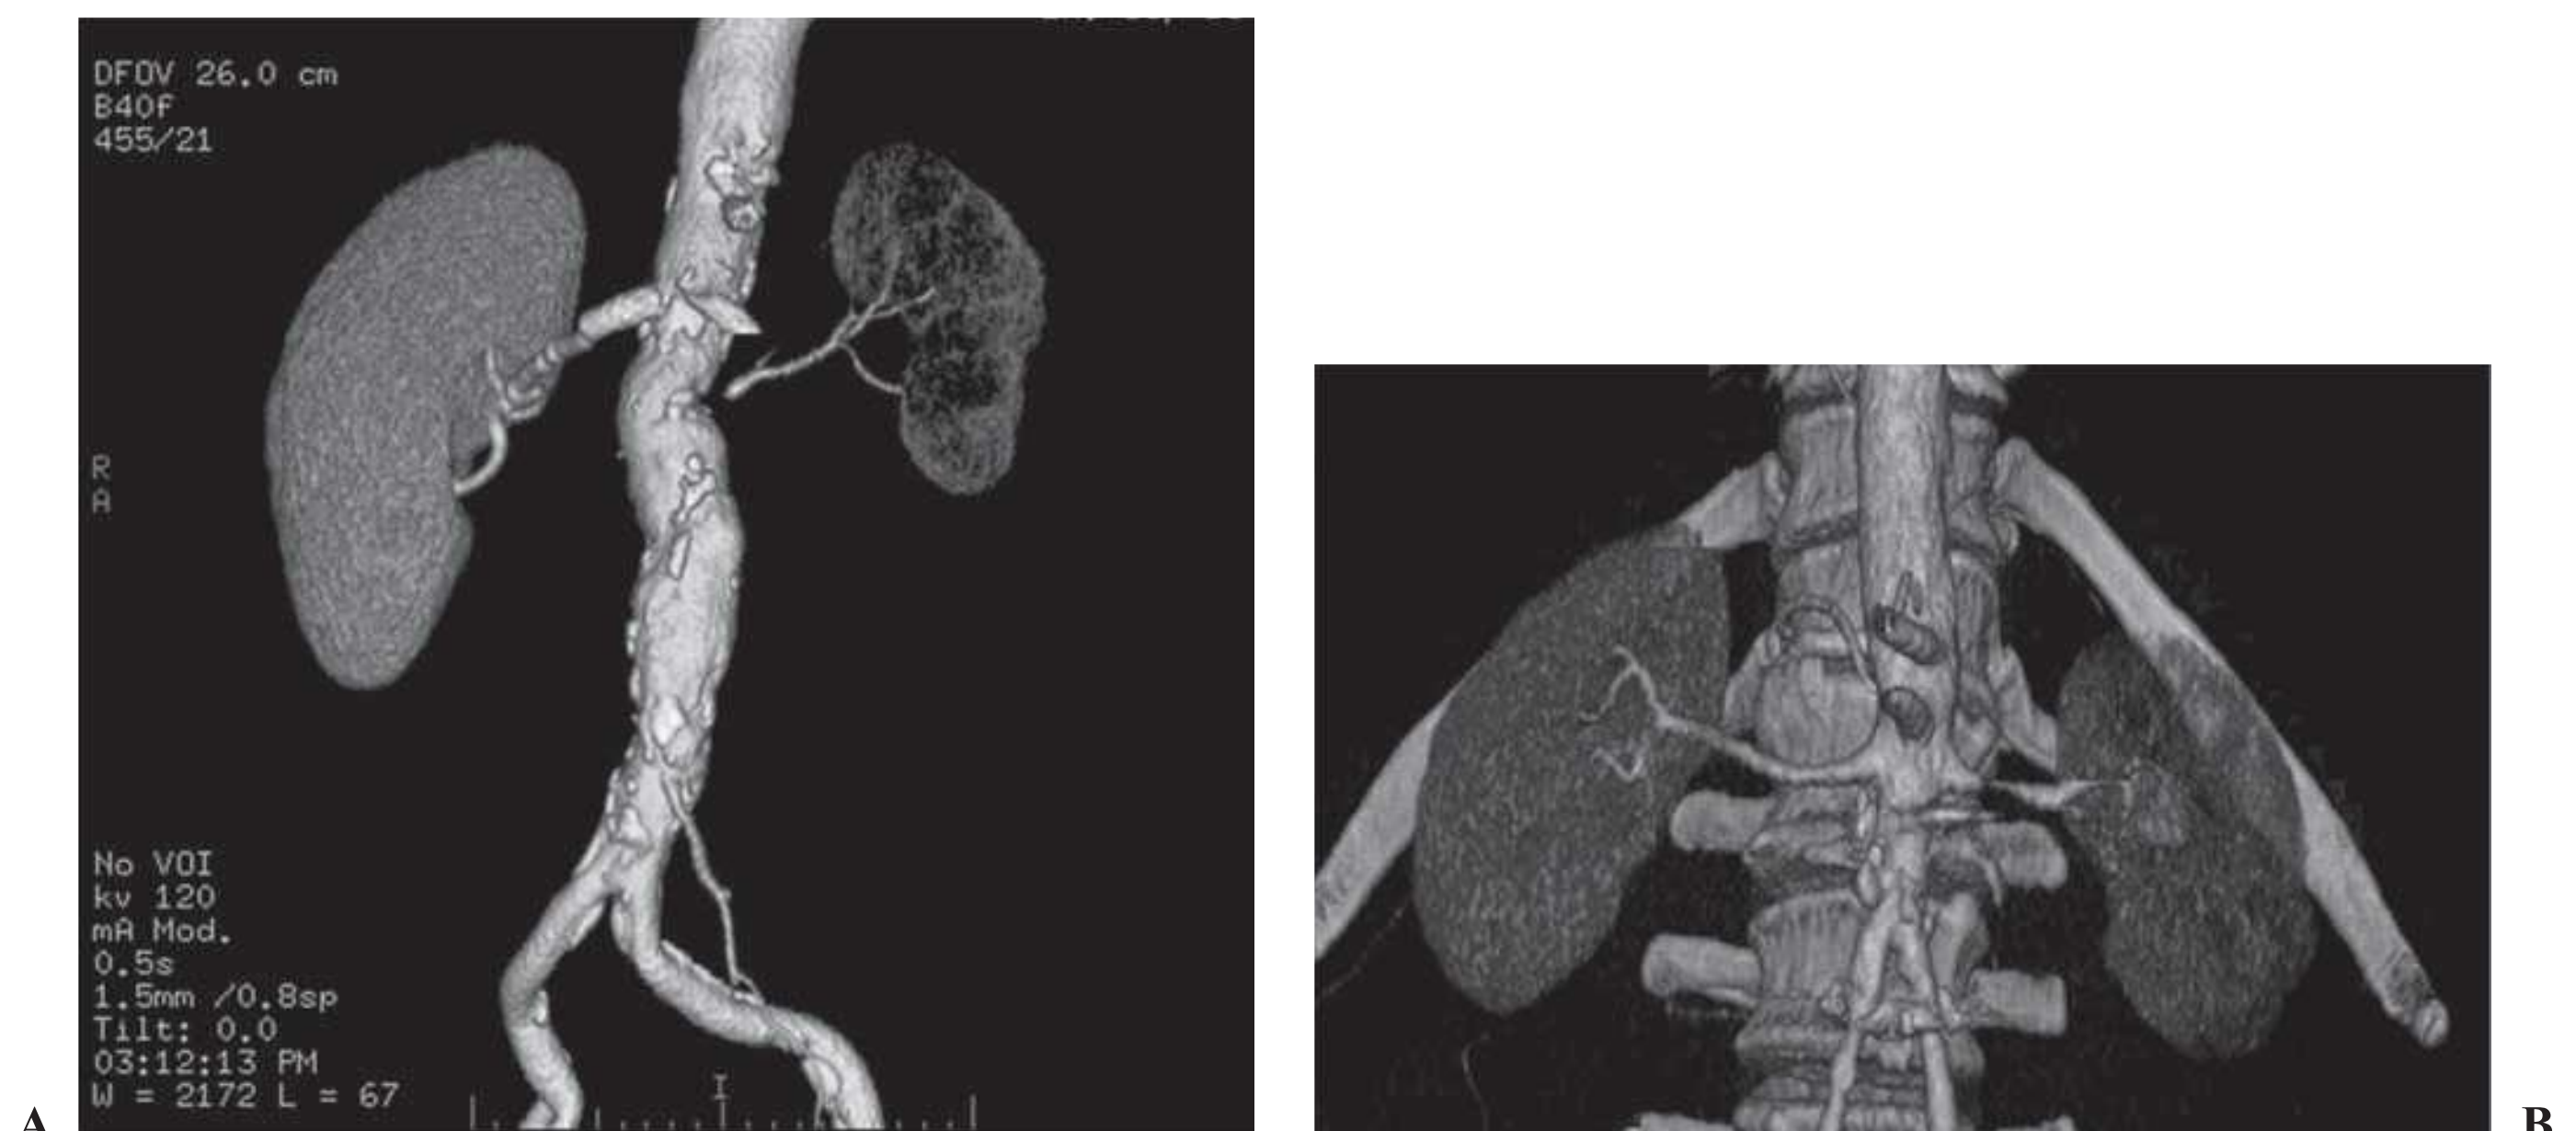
A and B: Computed tomography (CT) angiographic images with reconstruction can identify important elements of vascular anatomy and parenchymal function. A: A right renal artery stent with normal kidney parenchyma as compared with advanced renal artery stenosis affecting the left kidney, with evident loss of kidney size, perfusion, and function. B: A high-grade left renal artery stenotic lesion is evident with a moderate reduction in perfusion to the kidney as shown by its reduced size and the intensity of the nephrogram. (See Color Plate.)
